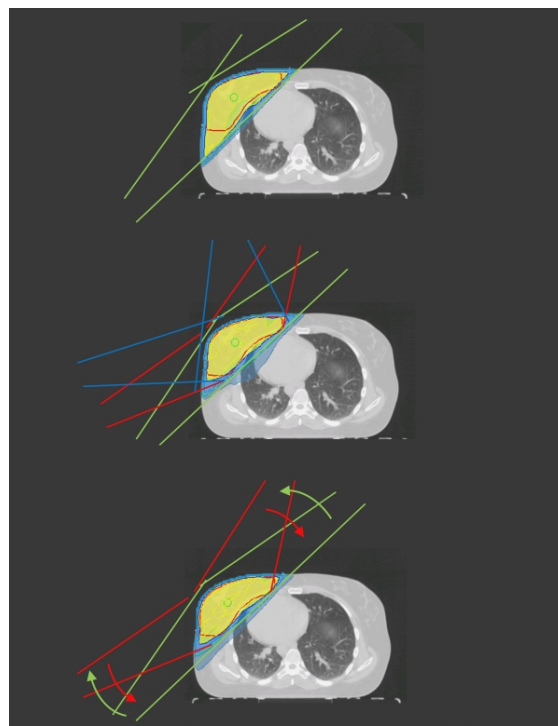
Summary of 20 patients, Treatment planning results (upper), dose distributions on CBCT's with offline correction (middle), dose distributions on CBCT with offline correction (lower)
